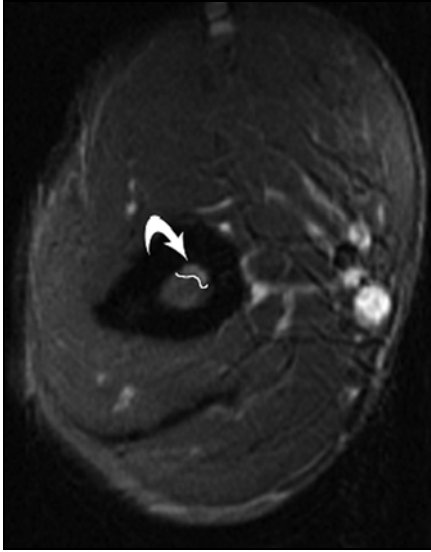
26-year-old male professional tennis player with mild distal humeral stress reaction. Axial STIR MR image of distal humerus shows mildly increased signal intensity (*arrow*) occupying less than 25% of cross-sectional area (*outlined*) of marrow cavity.
